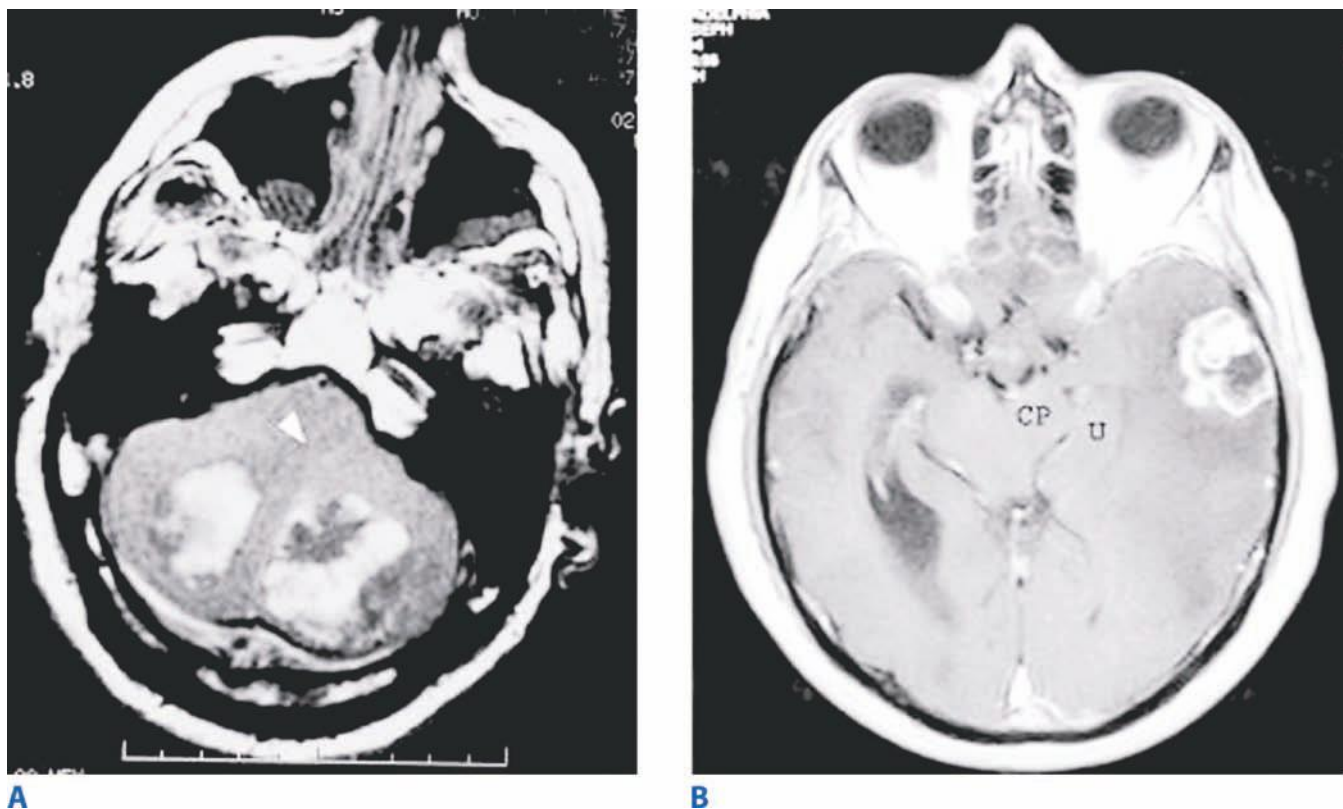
A. Precontrast T1-weighted axial magnetic resonance imaging demonstrating bilateral hemorrhagic cerebellar metastases. Patient presented with ataxia and then lethargy progressing to deep coma. This patient has total effacement of the fourth ventricle and severe brain stem compression. The fourth ventricle cerebrospinal fluid space should be at the tip of the *arrowhead*. Patient recovered to normal mental status after emergent posterior fossa craniotomy. B. Postcontrast T1-weighted axial magnetic resonance imaging demonstrating a ring-enhancing lesion in the lateral left temporal lobe with moderate edema. The uncus (*U*) is compressing the left cerebral peduncle (*CP*) and displacing the brain stem to the right.
